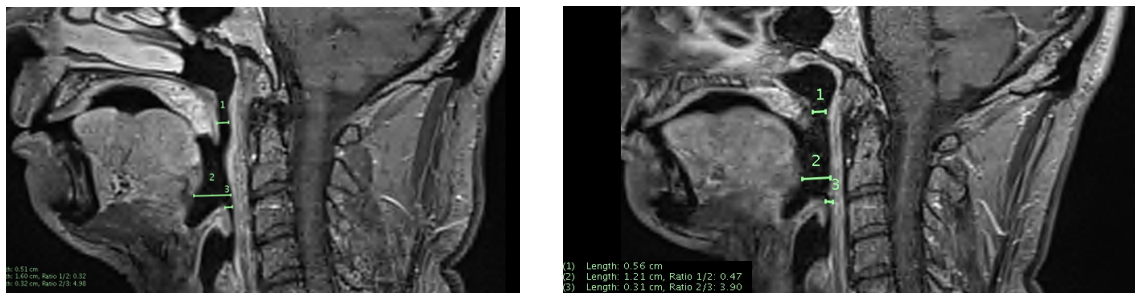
COMPARISON OF MESOPHARYNGEAL LUMEN USING MAGNETIC RESONANCE IMAGING (MRI) PRE- AND POST-TONGUE BASE AUGMENTATION PROCEDURE IN PARTICIPANT ONE.
